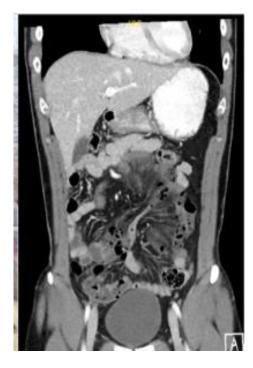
Coronal CT scan showing central mesenteric stranding and swirling mesenteric vessels-classic features suggestive of internal hernia.
